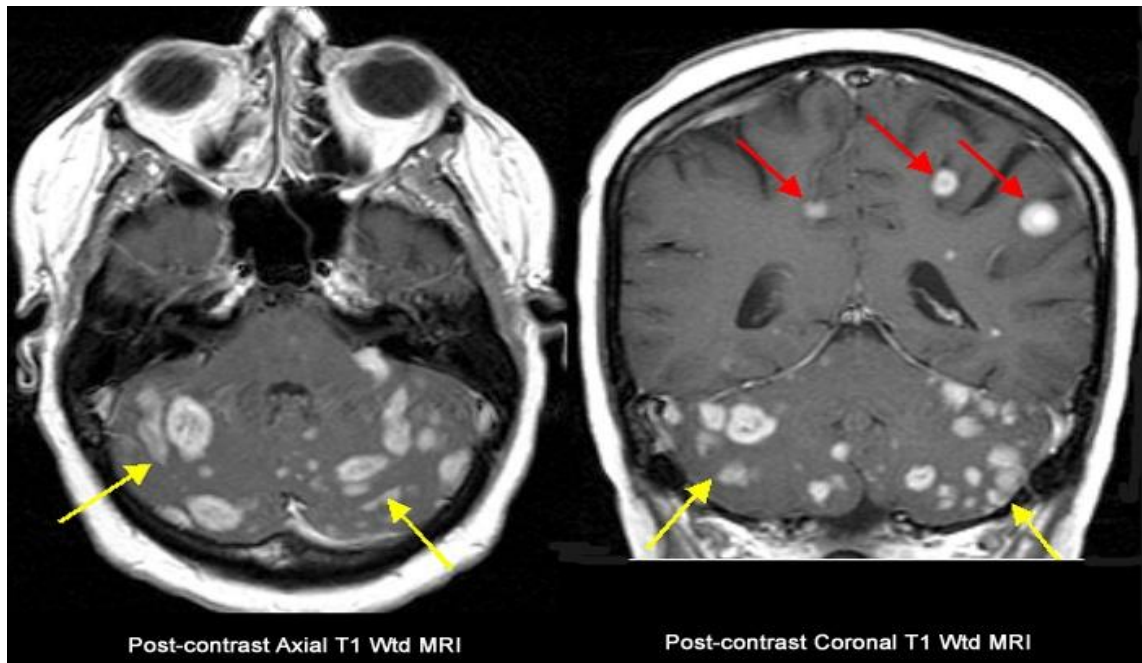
MRI scan showing multiple metastases to the brain
